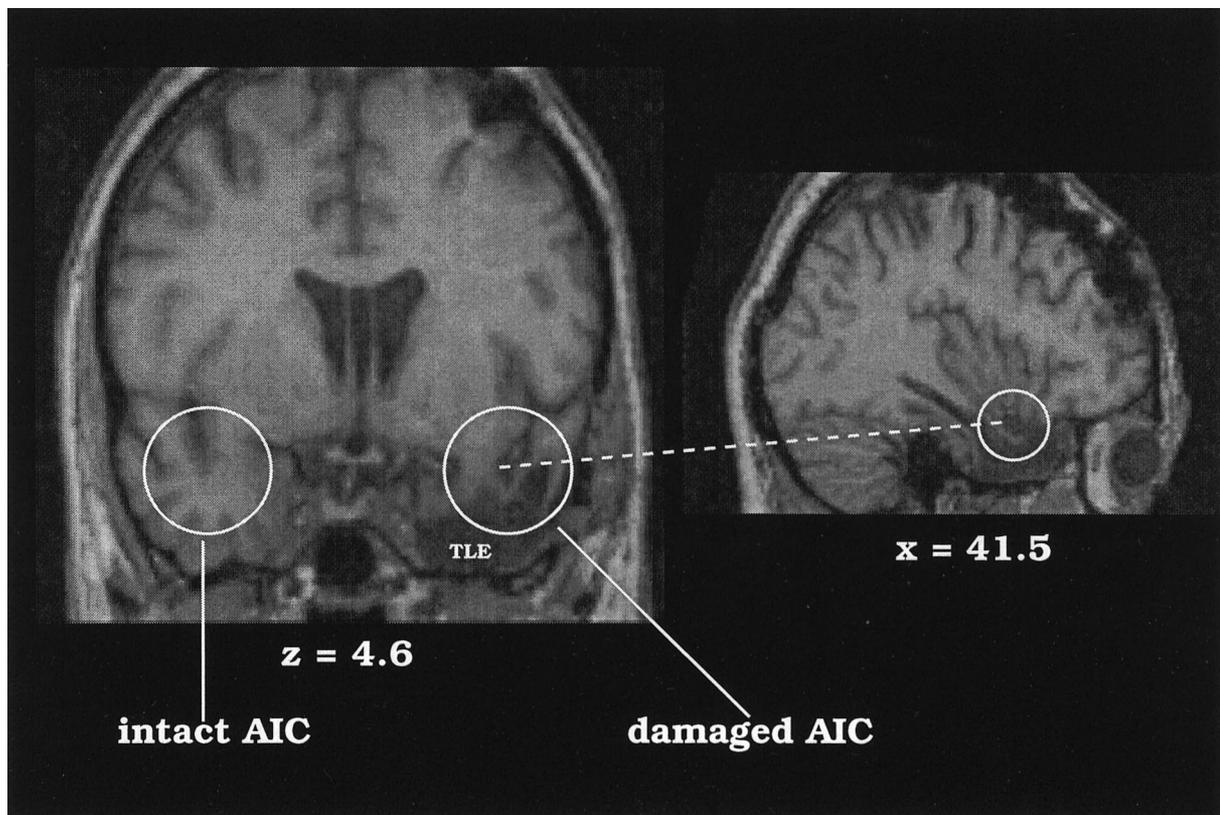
Resection of anterior insular cortex in the outlier. *Left*, Coronal section from the postoperative MRI of the subject whose detection threshold was also impaired. Note the healthy left insular cortex compared with the damaged agranular insular cortex (AIC) in the right hemisphere. TLE, Temporal lobe excision. *Right*, Sagittal section from the same MRI, showing damage in right hemisphere.
